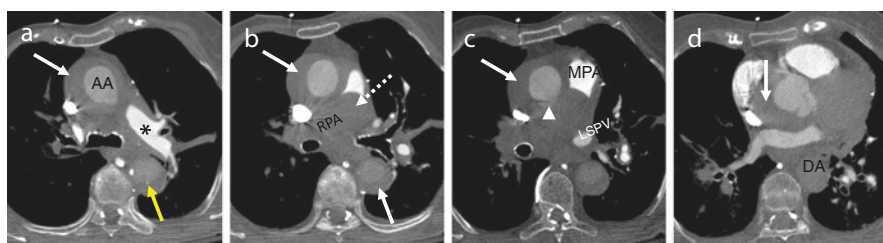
Sequential transaxial CTA images (a–d) demonstrate a ruptured type A IMH (arrows) in an 88-year old woman with chest pain. Mediastinal hemorrhage (dotted arrow) tracks into the shared adventitia between the aorta and pulmonary arteries causing severe narrowing of the main pulmonary artery (MPA) and occlusion of the right PA (RPA). The left PA (*) is narrowed but patent. Poor cardiac output results in diminished contrast in the descending aorta (DA). Note the ulcerlike projection arising from the posterior ascending aorta (AA) (arrowhead) and the displaced intimal calcification in the DA (yellow arrow) (a). LSPV Left superior pulmonary vein
